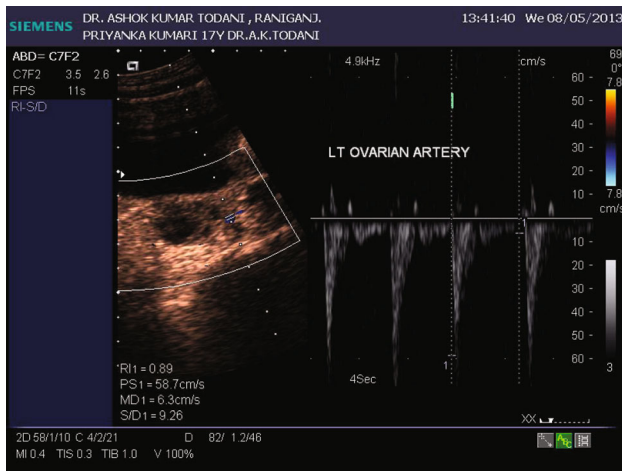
Colour Doppler of left ovarian artery
